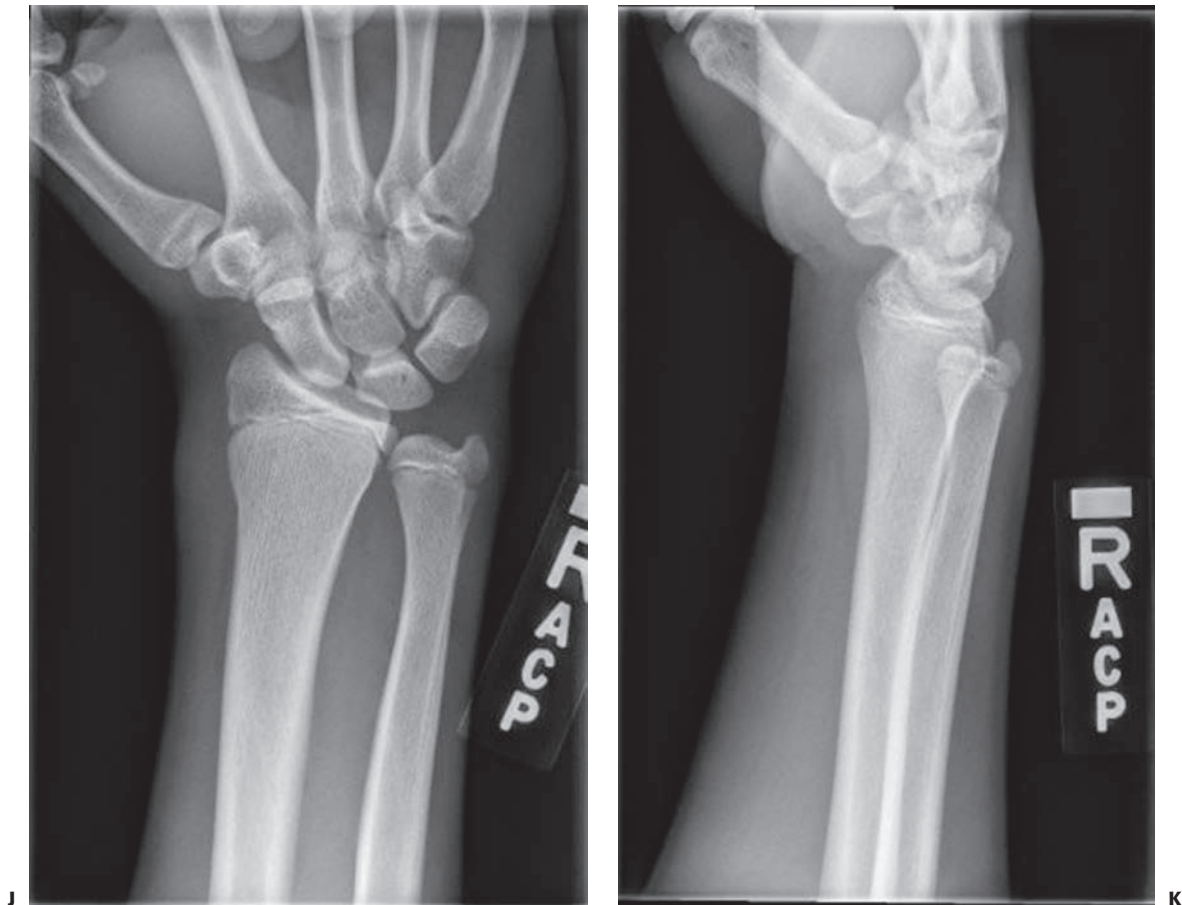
(continued) J: Thirty-nine month follow-up AP wrist radiograph and lateral (K) wrist radiograph (taken because of new trauma) demonstrating normal bony anatomy. Nails were removed 6 months postoperatively.
